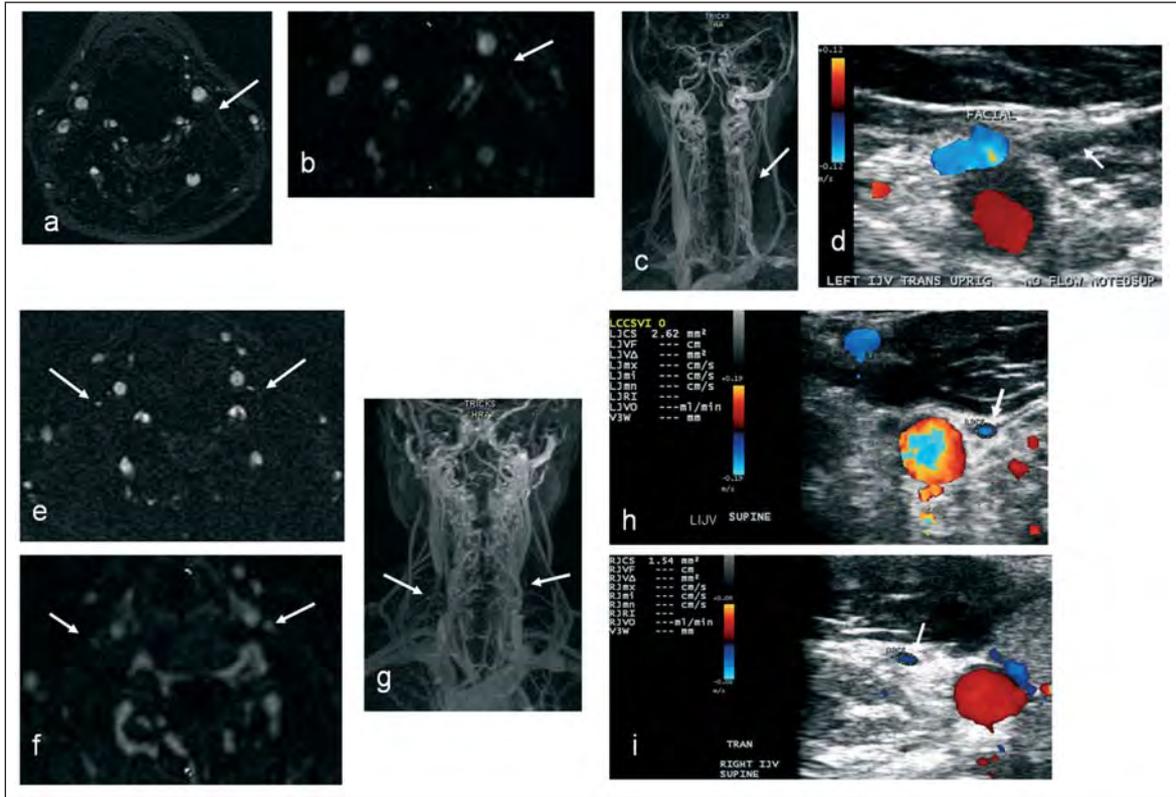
Examples of abnormal internal jugular vein (IJV) flow morphology on MR venography and Doppler sonography: (a) absent flow in left IJV on axial 2D time-of-flight and (b and c) on enhanced 3D time resolved imaging of contrast kinetics, and (d) no flow in left IJV on Doppler sonography; (e) pinpoint flow morphology in both IJVs on axial 2D time-of-flight and (f and g) on enhanced 3D time resolved imaging of contrast kinetics images; (h) Doppler sonography shows reduction of lumen and flow in the left IJV and (i) right IJV.
